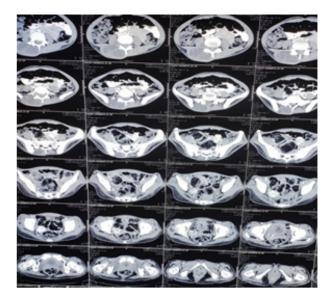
MRI with contrast study of lumbo sacral spine showing multiple cystic lesion
